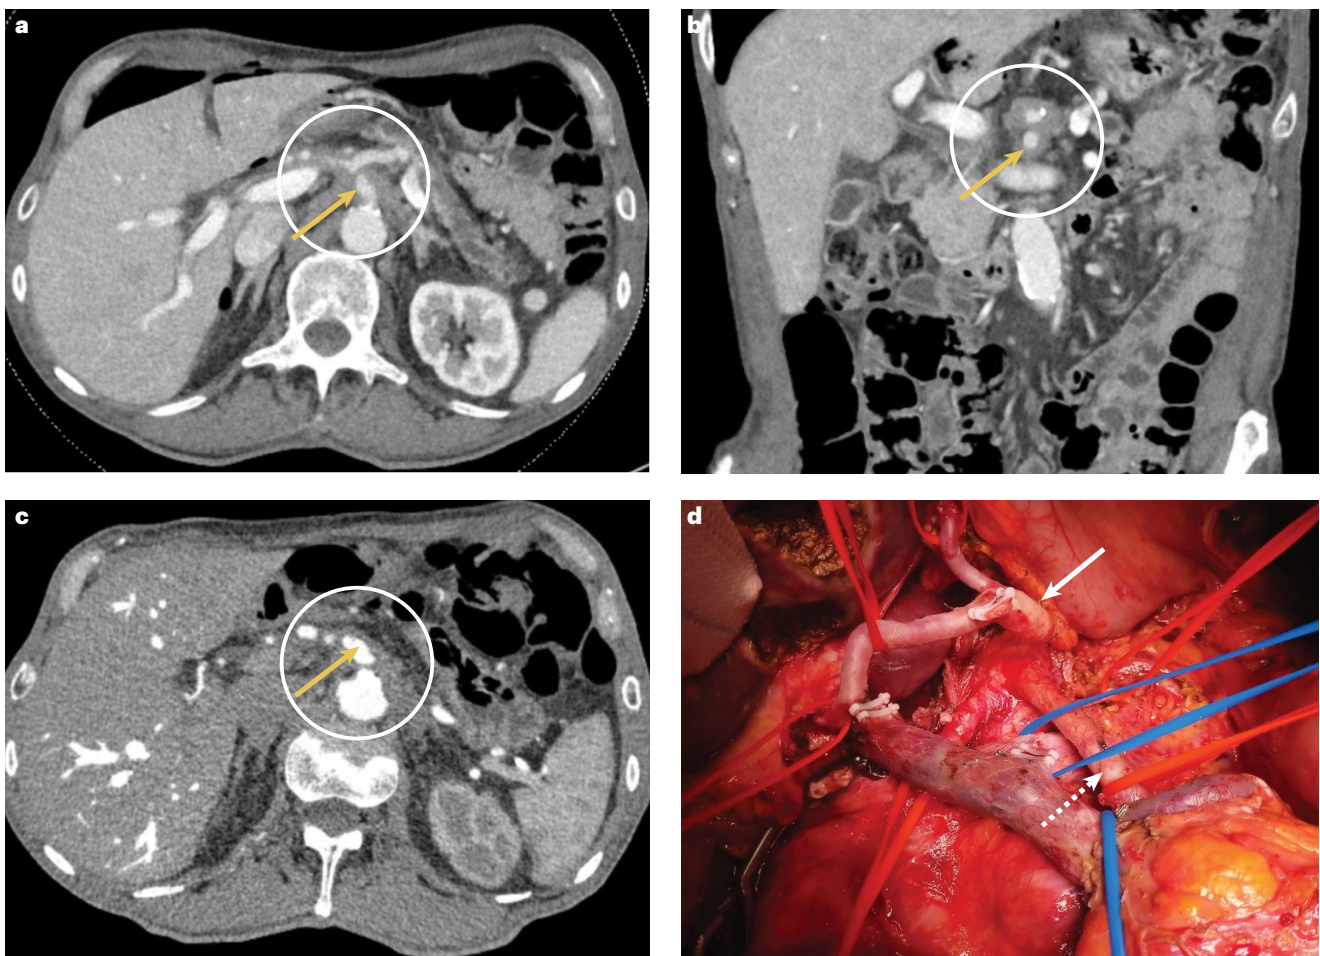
Resection of locally advanced pancreatic cancer after neoadjuvant therapy. Axial (panel a) and coronal (panel b) CT images in a patient with locally advanced pancreatic ductal adenocarcinoma (PDAC), demonstrating 360° encasement of the coeliac axis and superior mesenteric artery (yellow arrows), with aortic contact (white circles). The post-induction chemotherapy (mFOLFIRINOX) CT image (panel c) shows persistent 360° coeliac axis
